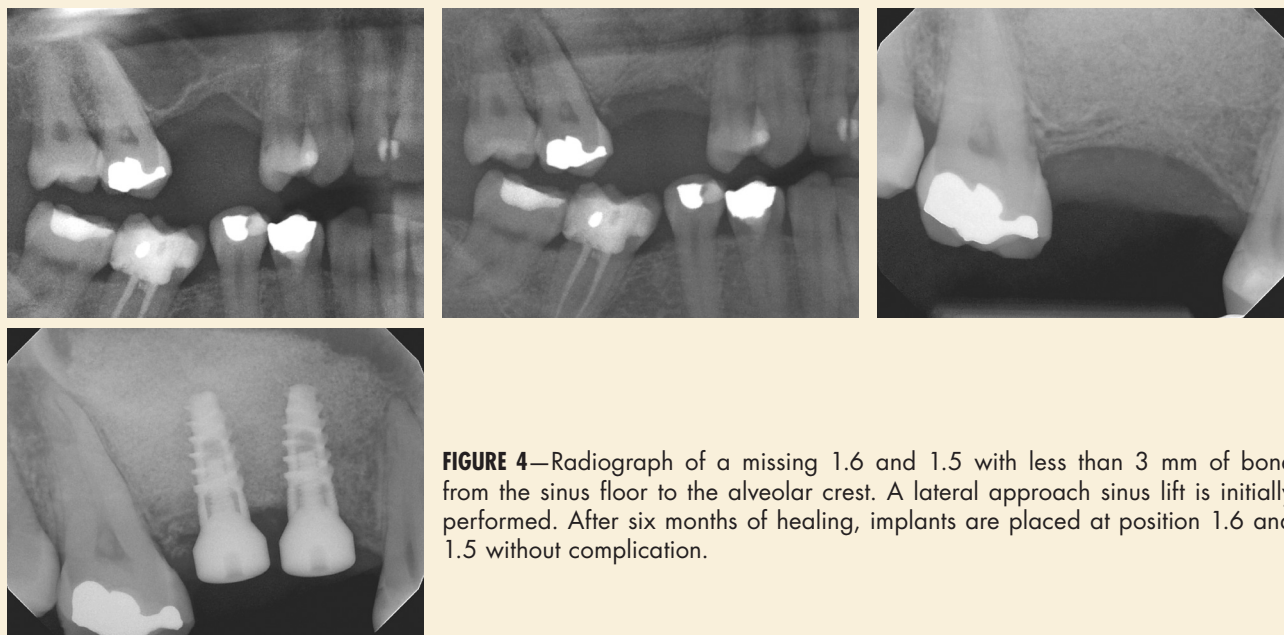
Radiograph of a missing 1.6 and 1.5 with less than 3 mm of bone from the sinus floor to the alveolar crest. A lateral approach sinus lift is initially performed. After six months of healing, implants are placed at position 1.6 and 1.5 without complication.
